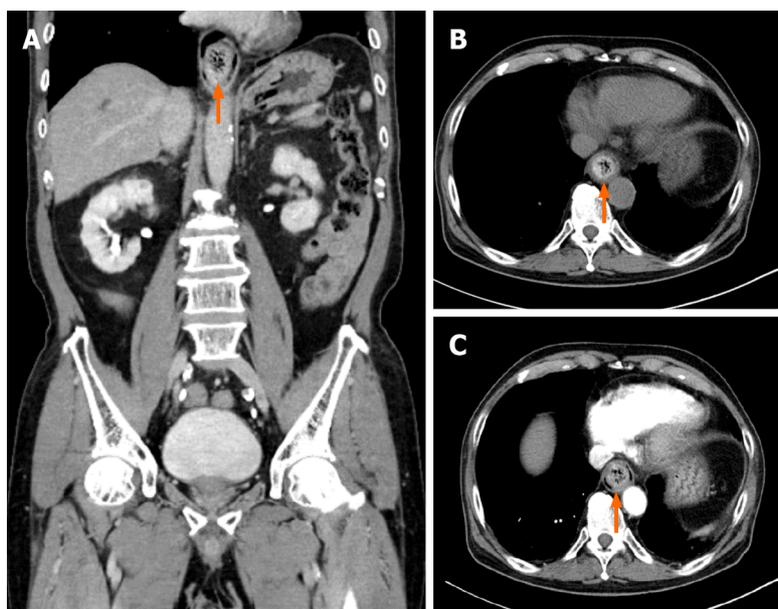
Abdominal computed tomography scans in the emergency department. The red arrows indicate an approximately 2.0 cm × 2.5 cm bezoar located just above the gastro-esophageal junction. A: Coronal view; B and C: Plain view.
